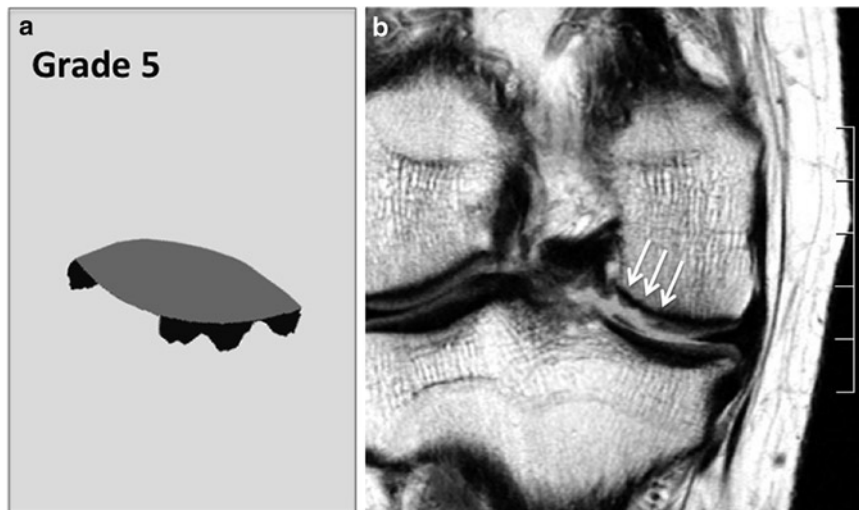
Whole-Organ-MRI-Score (WORMS) grade 5.* Graph of grade 5 knee cartilage lesion (a) and coronal proton density weighted fast spin echo sequence of the knee (b) showing a cartilage WORMS grade 5 lesion at the medial femoral condyle. The focal lesion measures
